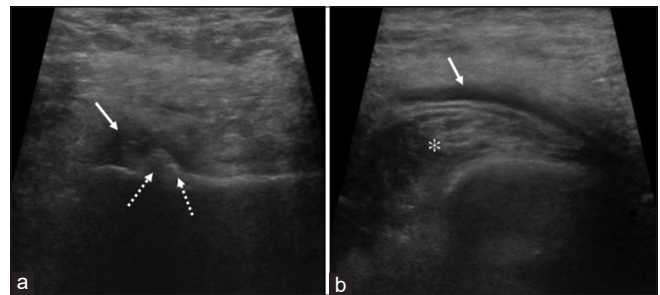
A 55-year-old female with upper thigh pain. Focused ultrasonography of the upper posterolateral thigh at the site of pain shows bony irregularity (dotted arrow) with adjacent hypoechoic soft tissue (white arrow in a), surrounding echogenic muscles (* in b), and thin fluid layering (white arrow in b).
